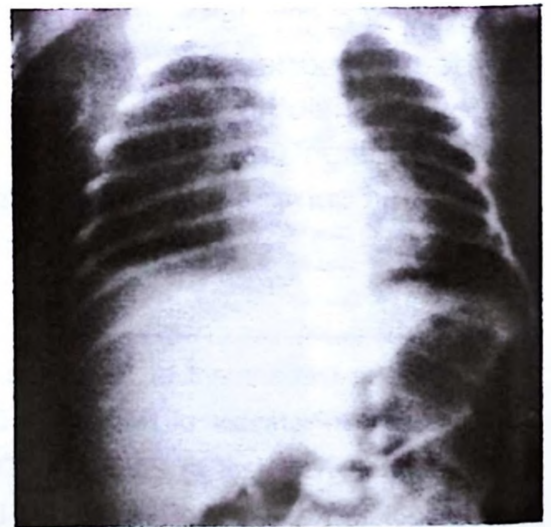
x-ray of the baby after thoracentesis.
